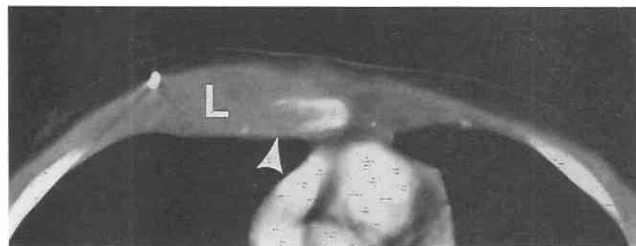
Recurrent large-cell lymphoma involving the chest wall of an 11-year-old boy. CT scan shows soft tissue mass (L) arising from the sternum (arrowhead) with associated bony destruction.
